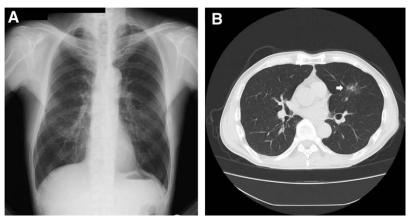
(A) CR of Case 15 described in Table 5. There was no abnormal opacity. (B) LDCT of Case 15 described in Table 5. There was a ground-glass opacity on the left lower lobe (white arrow). This case was diagnosed as stage I lung cancer. CR = chest radiography, LDCT = low-dose computed tomography.
